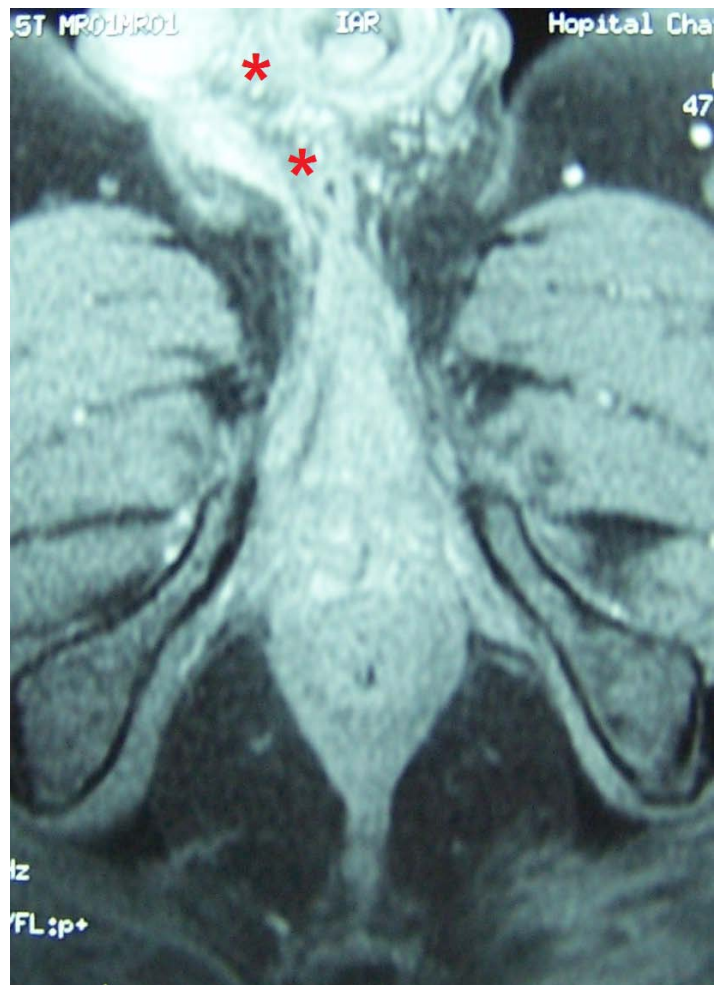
MRI of pelvis shows well-circumscribed abscess with central area of low attenuation and peripheral rim enhancement.
